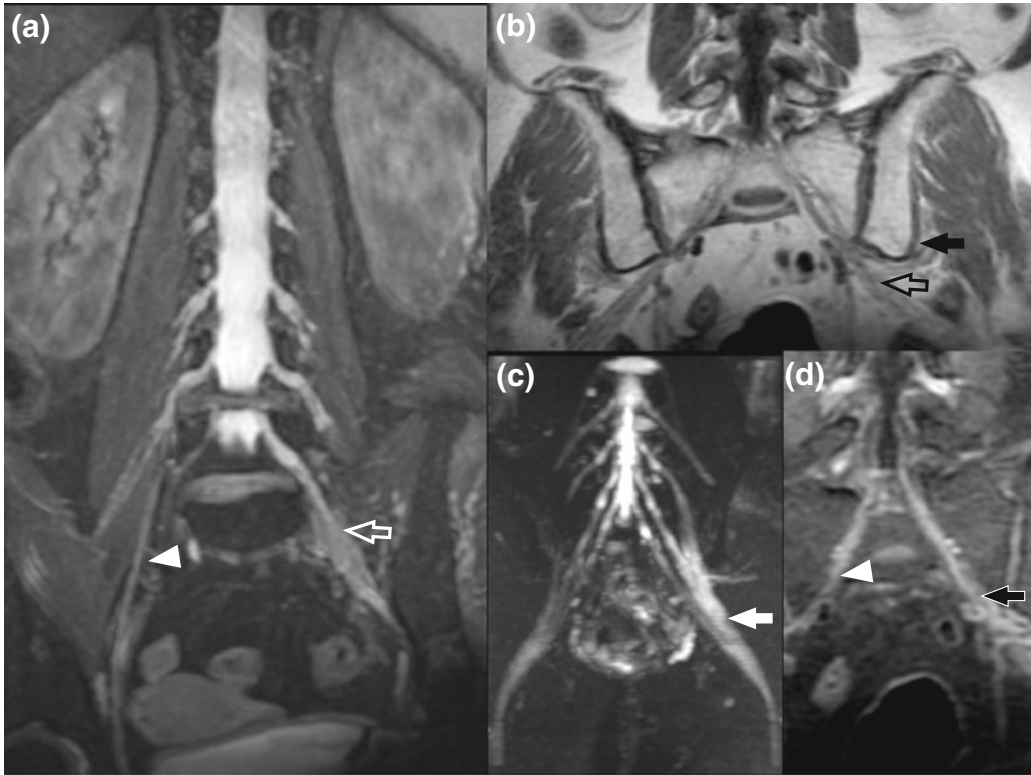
Diabetic lumbosacral radiculoplexus neuropathy (DLRPN): 70 year old female with diabetes mellitus II. Left chronic hip and thigh pain progressing over two months. Weakness in both lower limbs coincident with previous 9 kg of weight loss. Saphenous nerve biopsy demonstrated vasculitis. Sequence 3D IDEAL coronal FAT SAT T2-weighted image (a): asymmetric enlargement of left L5 nerve and proximal sciatic nerve (white arrow) compared to contralateral (white arrowhead).
